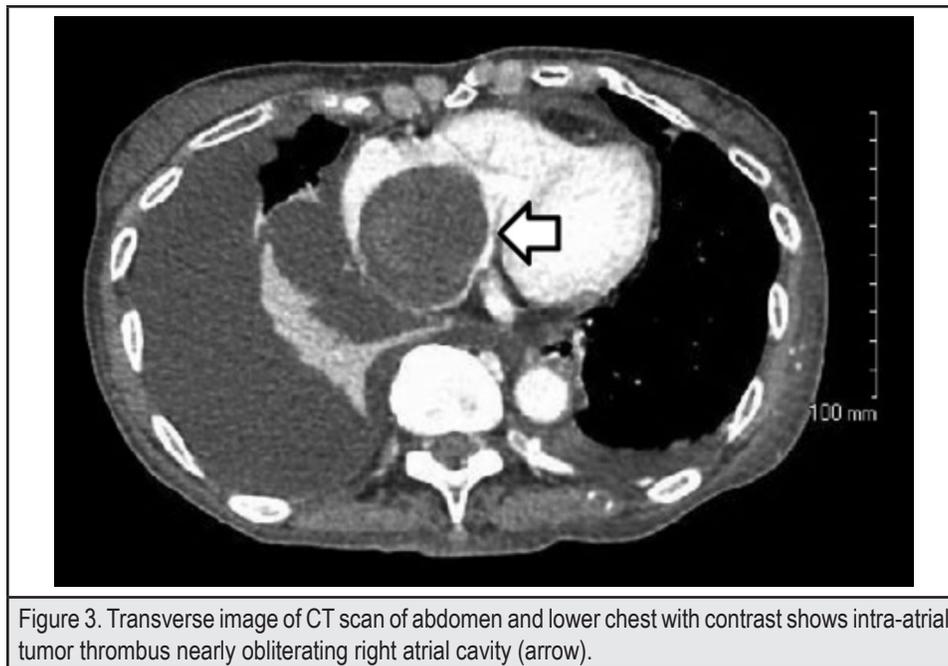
Transverse image of CT scan of abdomen and lower chest with contrast shows intra-atrial tumor thrombus nearly obliterating right atrial cavity (arrow).
